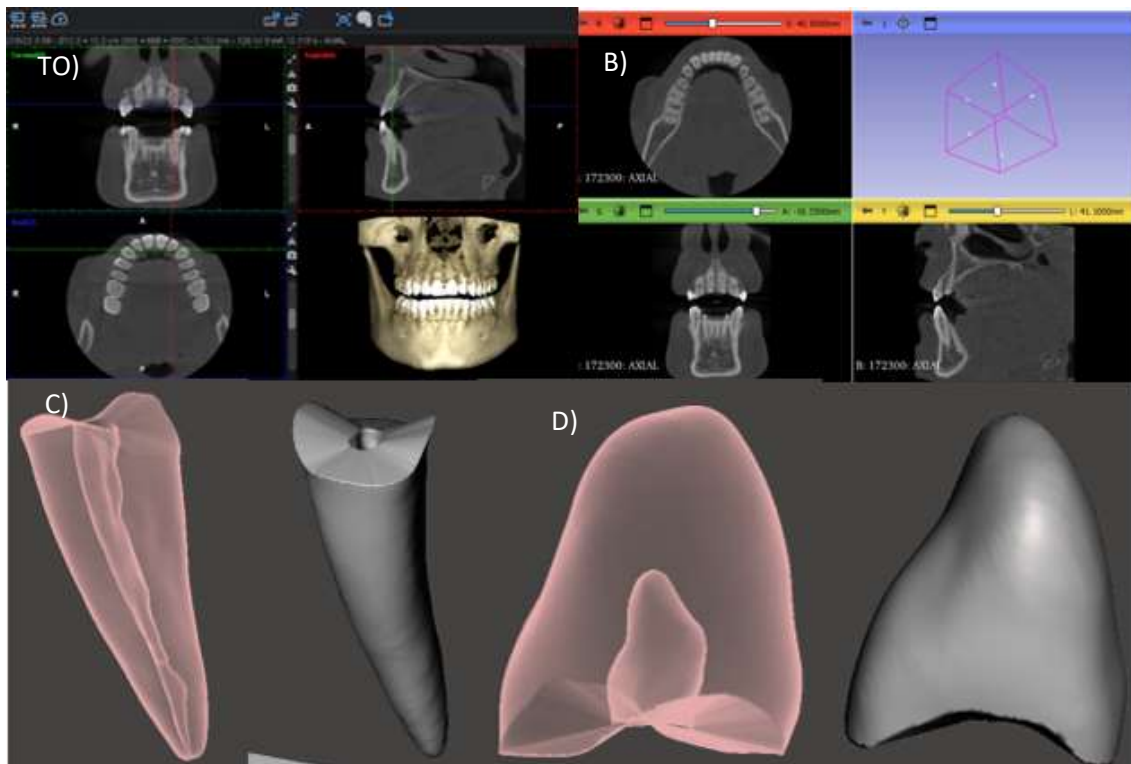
A) CBCT file of selected patient, B) DICOM export in 3dslicer software, C) root and canal modeling of dental piece in meshmixer, D) coronal modeling of dental piece in meshmixer
